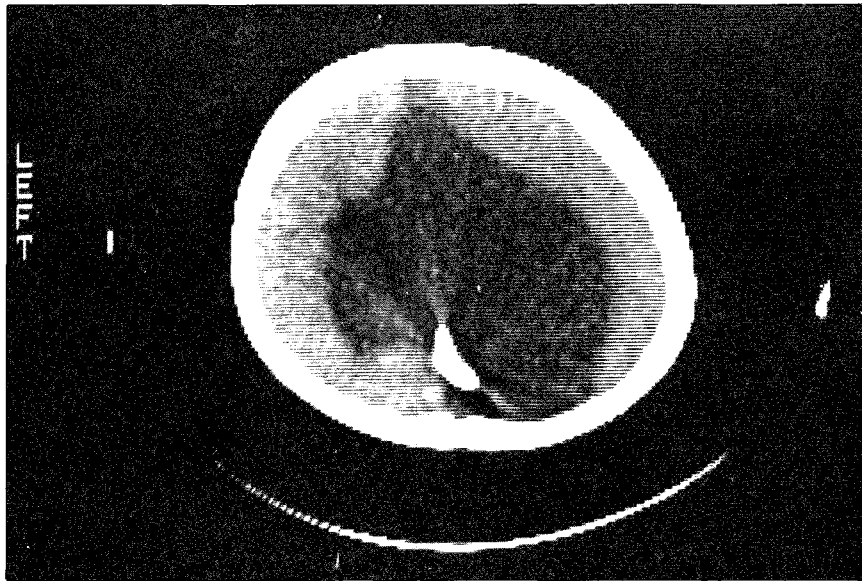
CT scan showing another metallic component in the porencephalic cyst consistent with the right angled connector.
